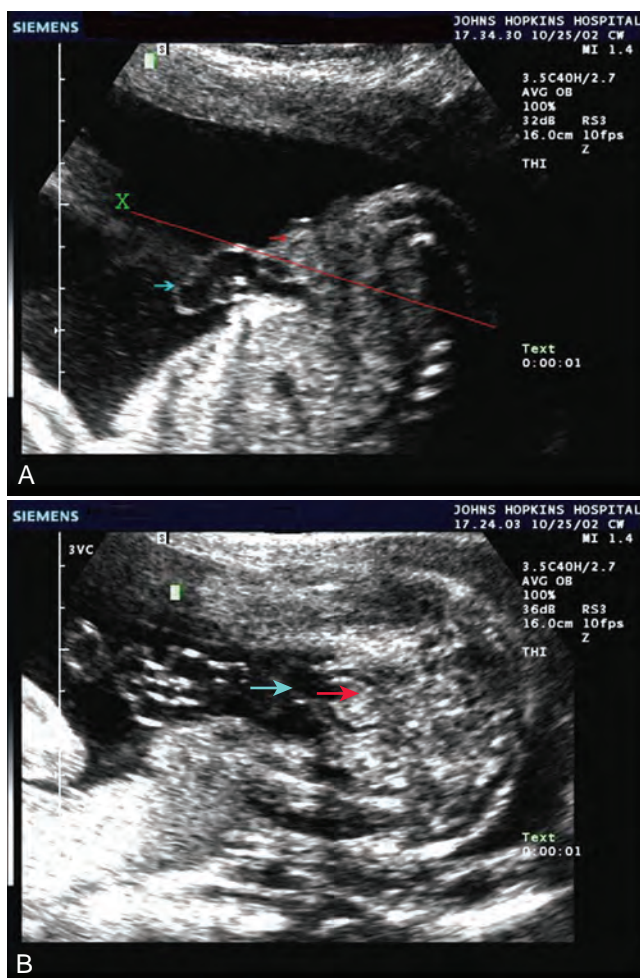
Prenatal ultrasound scan demonstrating bladder exstrophy. A, Longitudinal view showing the low-set umbilicus (cyan arrow), lack of intra-abdominal bladder, and lower abdominal mass (red arrow). B, Transverse view through the plane (X) in A shows presence of the umbilicus (cyan arrow) and the upper edge of the bladder plate that appears hyperechoic (red arrow).
